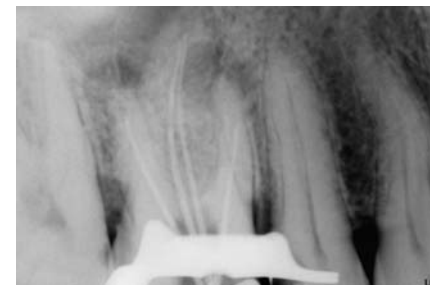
Mastercone intra oral periapical x-ray.
